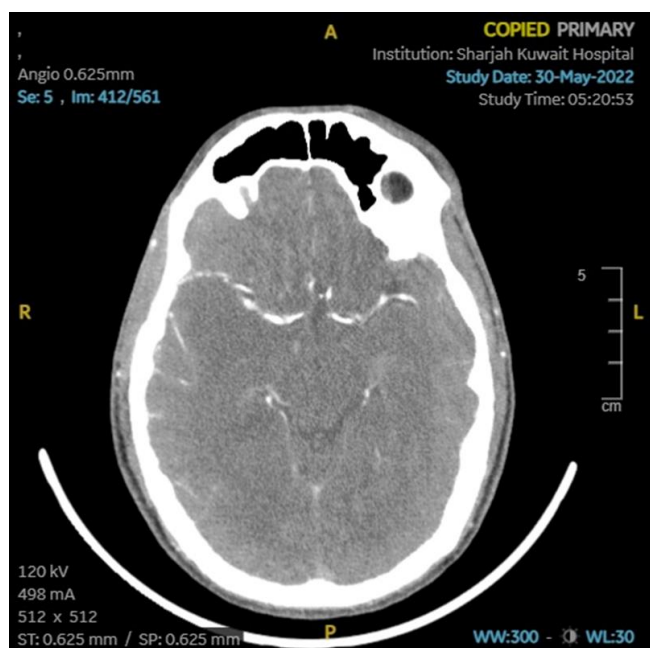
CT brain contrast images showing normal middle cerebral artery on both sides
